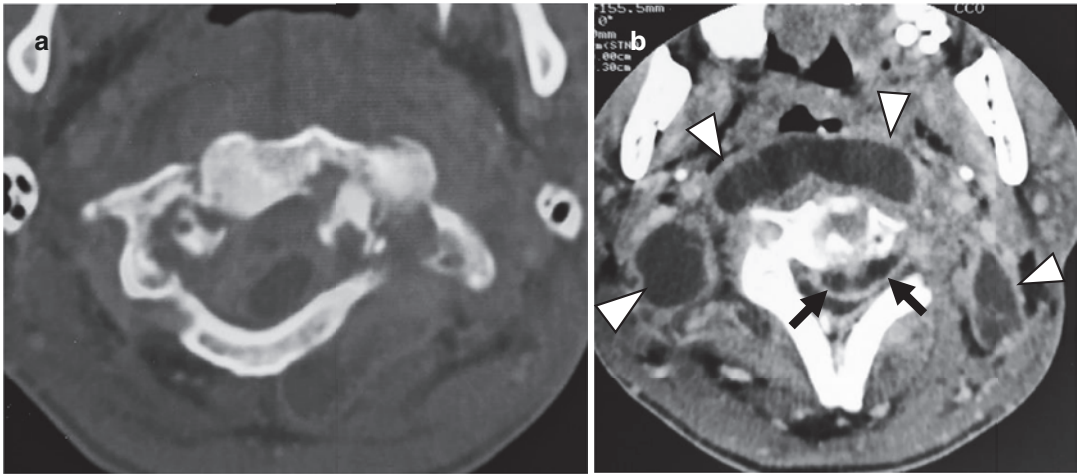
Craniocervical junction tuberculosis. Axial CT images taken in (a) bone and (b) soft tissue windows show destruction of C1 and C2 vertebrae with atlanto-axial dislocation, epidural (black arrows) and paravertebral (white arrowheads) abscesses
